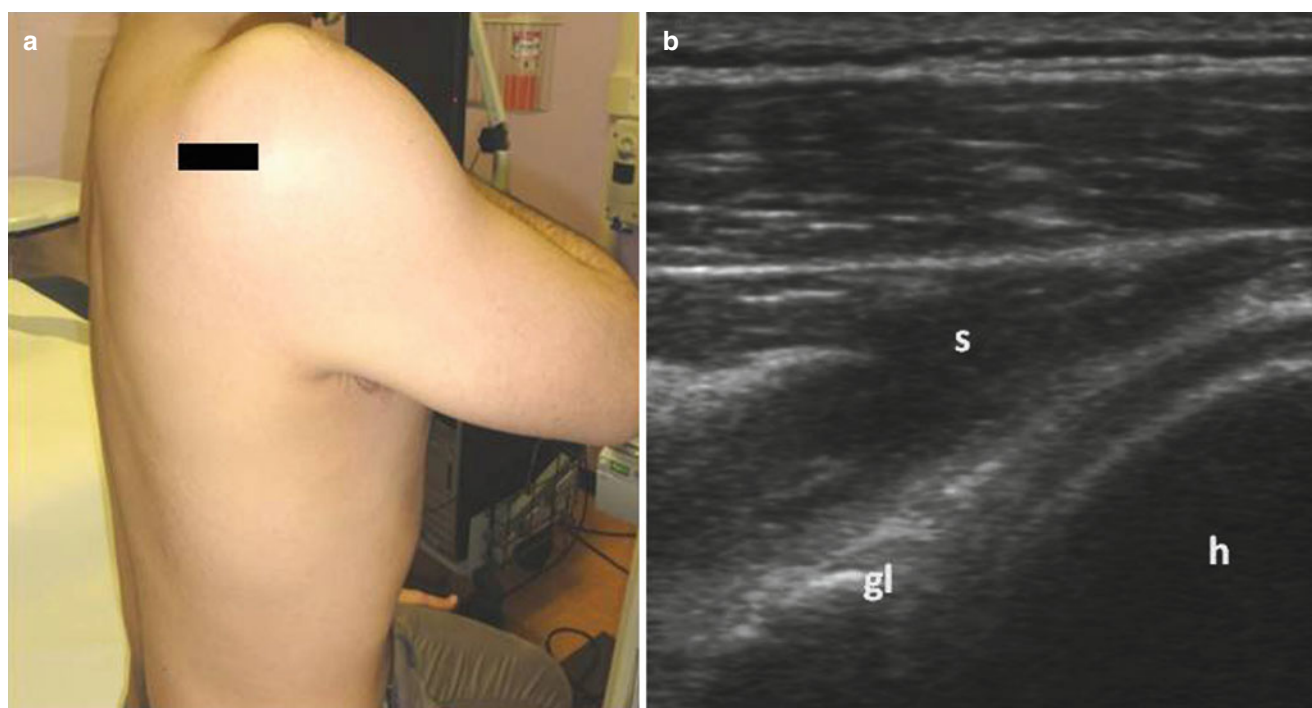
Sonographic scanning technique to optimize visualization of the infraspinatus and teres minor tendon; the fibers of these tendons can be stretched. This is accomplished by bringing the patient's arm in front of the body. The arm is flexed and adducted with his or her hand resting on the contralateral shoulder. The transducer is placed on an axial plane
